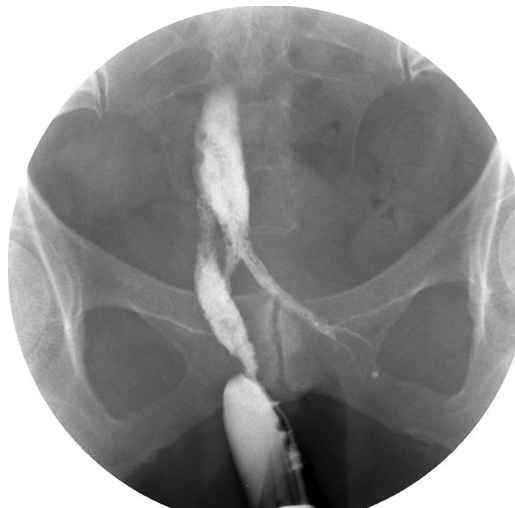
Fistulography: X-ray taken after contrast injection through the opening in the upper third of the right vaginal wall showing the length, shape and direction of the fistulous tract.
